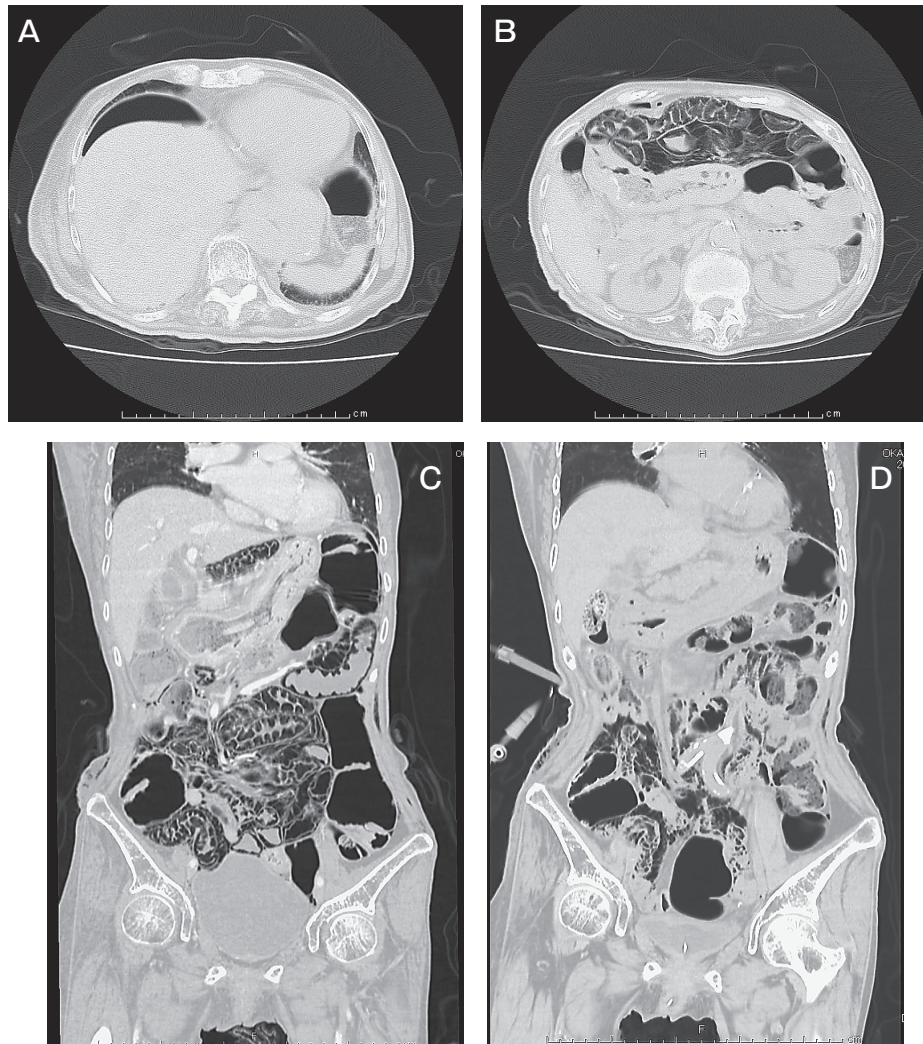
Abdominal CT. A, Intraperitoneal free air is apparent on the surface of the liver in the upper abdominal area; B, C, Gas image in the intestinal tract wall, mainly in the small intestine; D, On CT conducted 2 days after hospitalization, the gas image shows a decreasing tendency.
